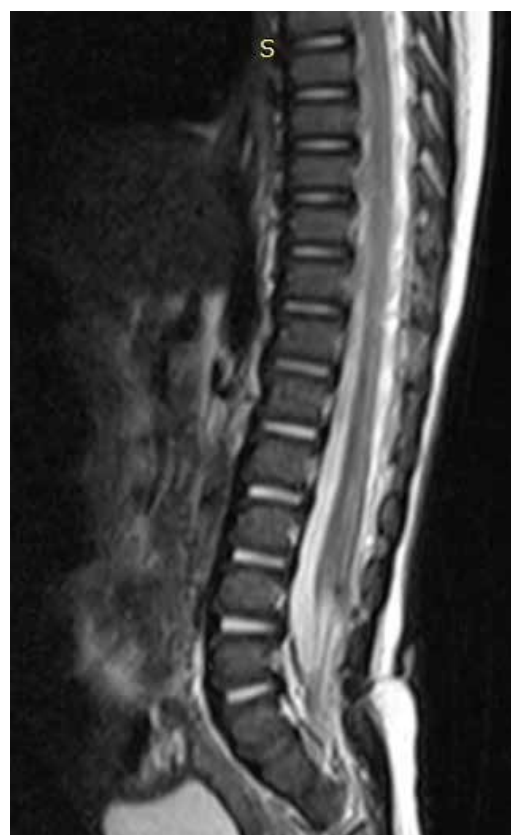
Magnetic Resonance Imaging (MRI) of the spine after birth showing the dermal sinus tract..
